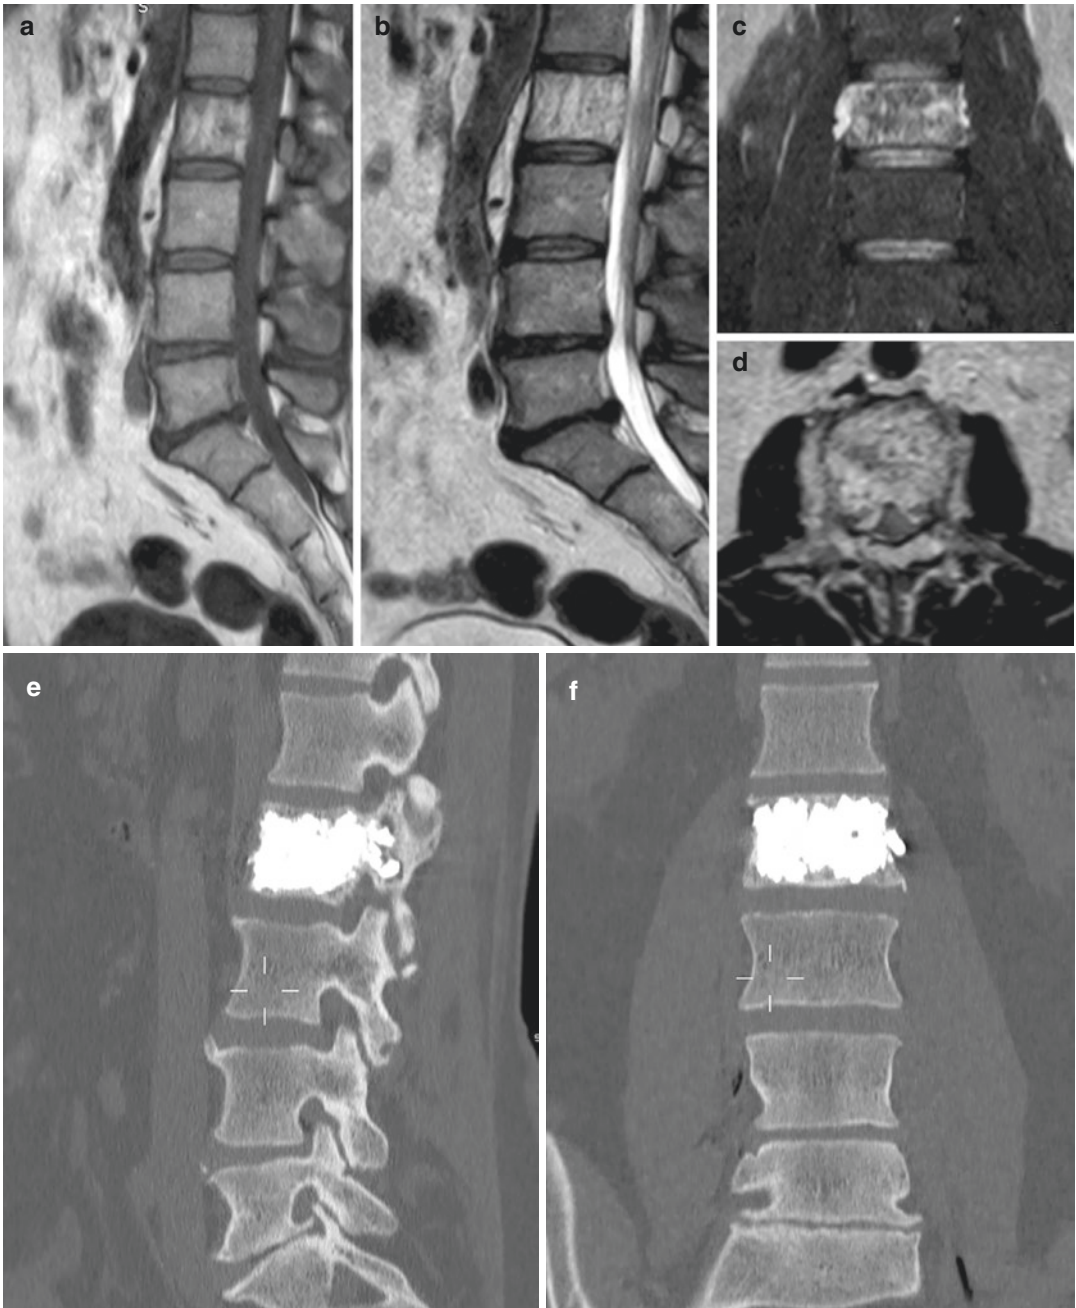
(a–d) MRI shows aggressive osteoangioma at L2 level with disomogeneous signal intensity in T1-weighted and T2-wieghted imaging and epidural extension more
